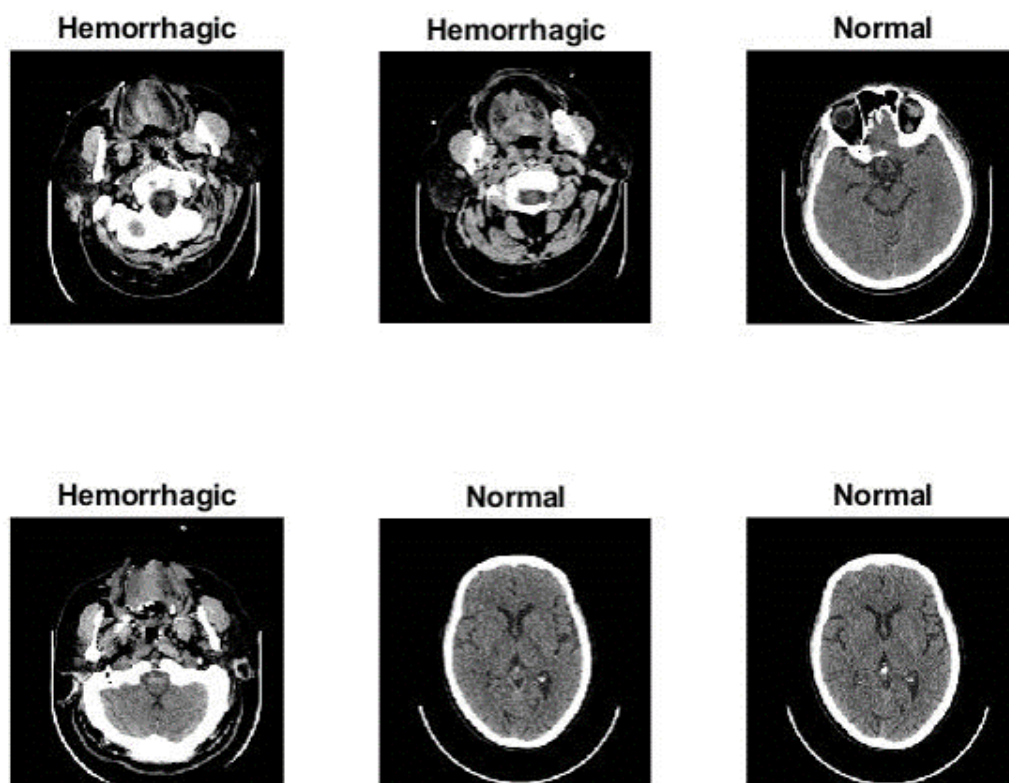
Set of CT images of a hemorrhage after image enhancement.
